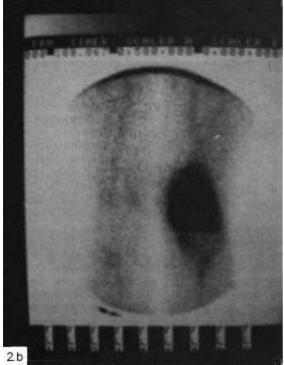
A normal scintigram obtained with ^{99m}Tc-GP(a) and a patient with multiple vertebral metastases (b) showing diffusely increased uptake of the vertebrae. Adenocarcinoma metas tosis to vertebral column was confirmed by biopsy.
